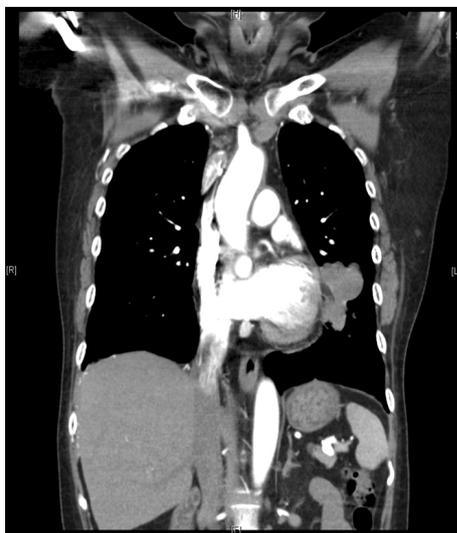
Chest computed tomography shows lung metastasis of leiomyosarcoma to the left upper lobe and left lower lobe.
